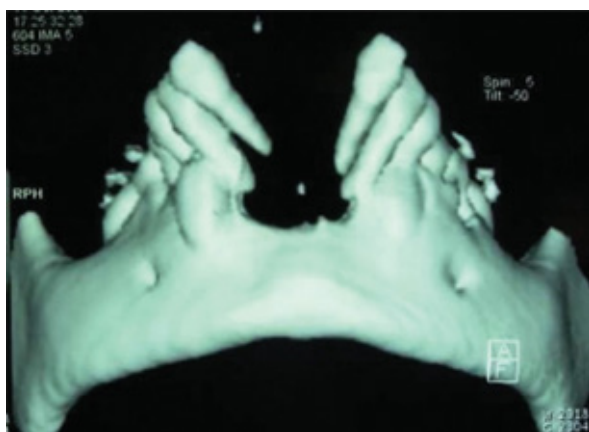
Three-dimensional computed tomography showing well-demarcated lesion with few radiopaque spicules
